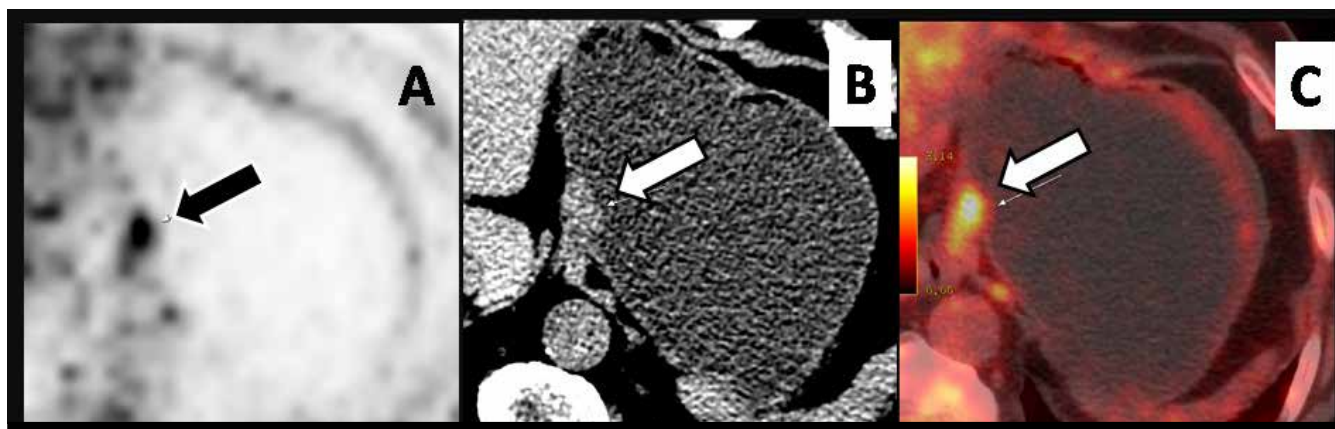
Mild-to-moderate hypermetabolic (A) nodular lesion is clearly seen at the cardia region on CT (B) and fusion image (C) of water-filled stomach with normal gastric wall thickness.
